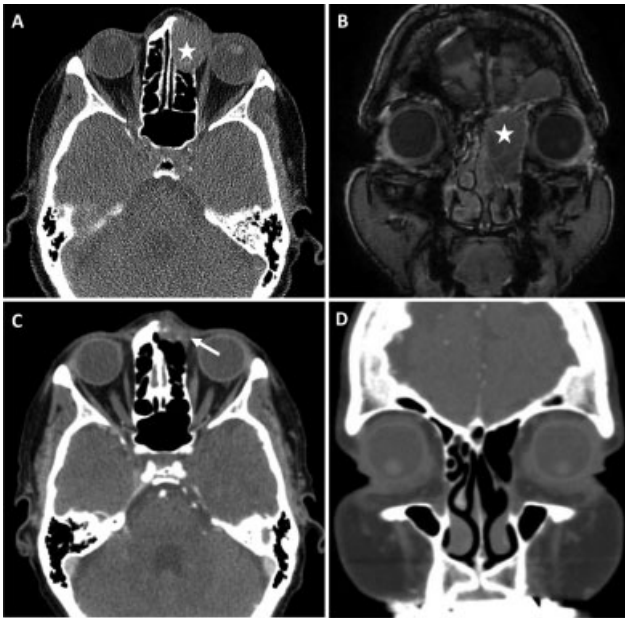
Pre-induction chemotherapy CT (A) and MRI (B) images of a left ethmoid SNSCC (star) which is seen in close proximity to the medial rectus muscle with no clear plane between tumor and periorbita. This would historically require an orbital exenteration to ensure negative margins. Post-induction chemotherapy CT images (C, D) in the same patient show a significant reduction in tumor volume, with no evidence of persistent tumor near the lamina papyracea (D). There is apparent persistent disease within the frontal sinus (C, arrow), for which orbit-sparing surgical resection was undertaken.
